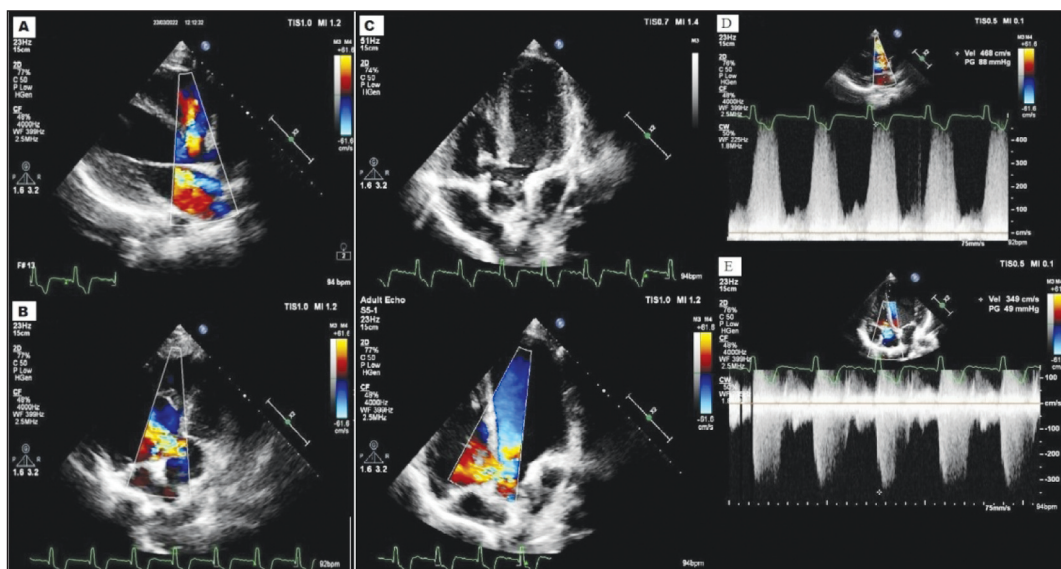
A) VSD echocardiographic color Doppler PLAX view; B) VSD echocardiographic color Doppler Parasternal Short Axis view; C) VSD echocardiographic 2D and color Doppler Apical five chamber view; D) The pressure gradient through VSD by using Doppler echocardiography at PLAX view; E) The velocity of tricuspid valve regurgitation by using Doppler echocardiography at Apical four chamber view.
